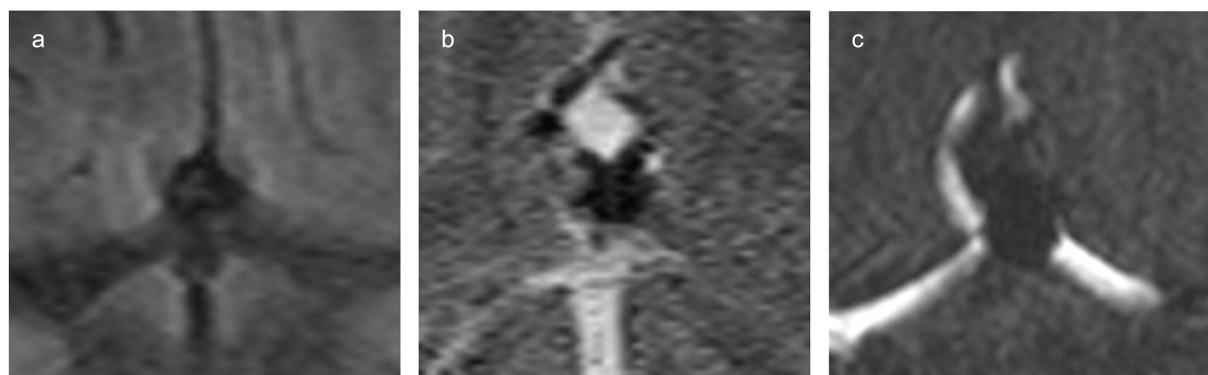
Follow-up MRI performed the next day demonstrates impaired visualization of the Contour Neurovascular System due to susceptibility artifacts: (a) FLAIR, (b) T2-weighted turbo spin-echo (TSE), (c) Time-of-flight MR angiography.
